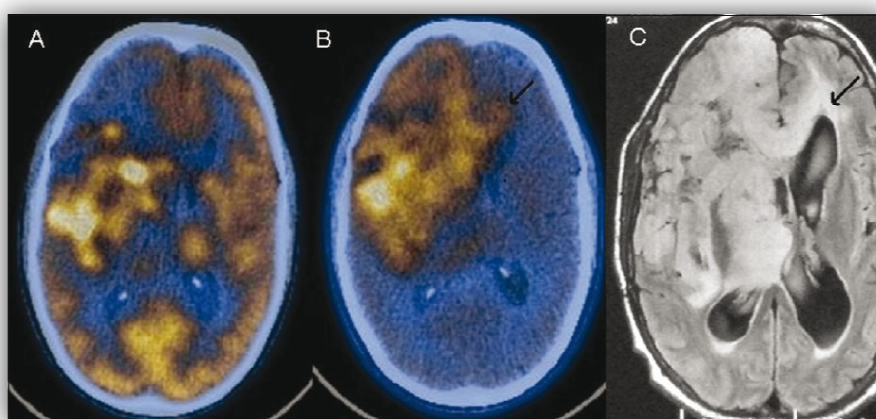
Post-operative study of a low-grade right frontal astrocytoma. Image (A) corresponds to a FDG PET/CT scan, showing residual tumour in the right fronto-parietal region. Image (B) from a PET/CT scan with F-DOPA, facilitates the delineation of the actual extent of the lesion (arrow), which appears to cross the midline, as proven by the FLAIR axial MRI image (C) (46).
